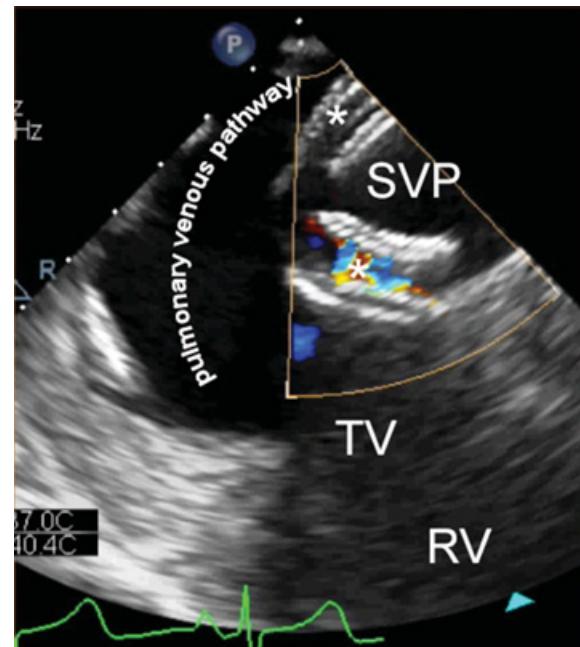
An ME four-chamber color flow Doppler view with the probe turned toward the right. This is a zoomed imaged similar to Figure 22.6. Two septal occlusion devices are visible (marked with an asterisks).
